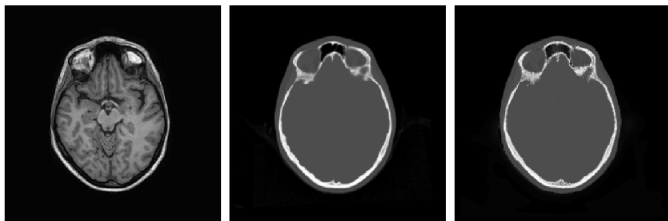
Axial images of the patient-specific MR (left), patient-specific CT (center), and estimated pseudo-CT using our approach (right).
